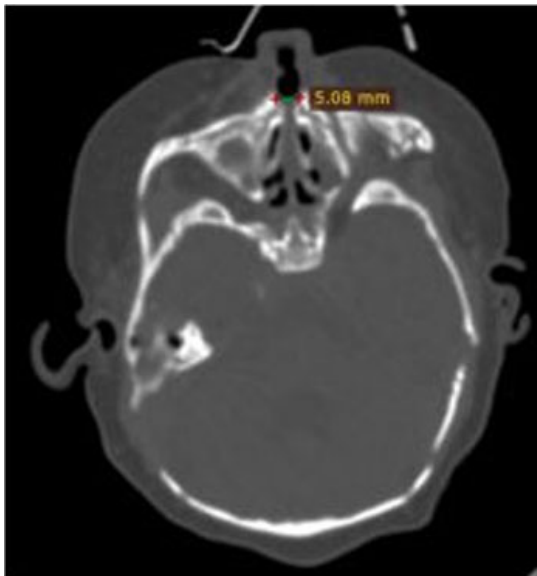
Axial CT image showing pyriform aperture stenosis.
